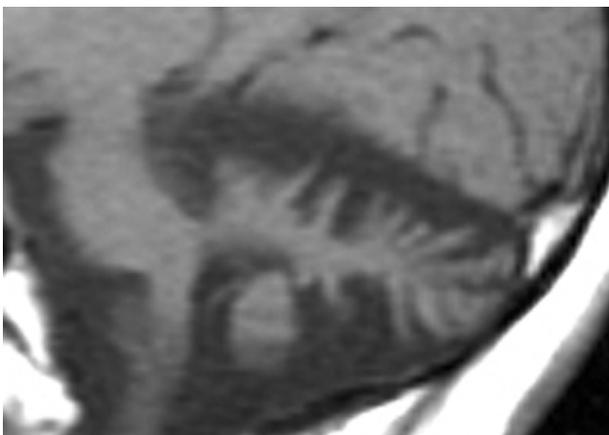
T1-weighted sagittal MRI of the cerebellum in case 23 with Behcet's disease showing cerebellar atrophy.
